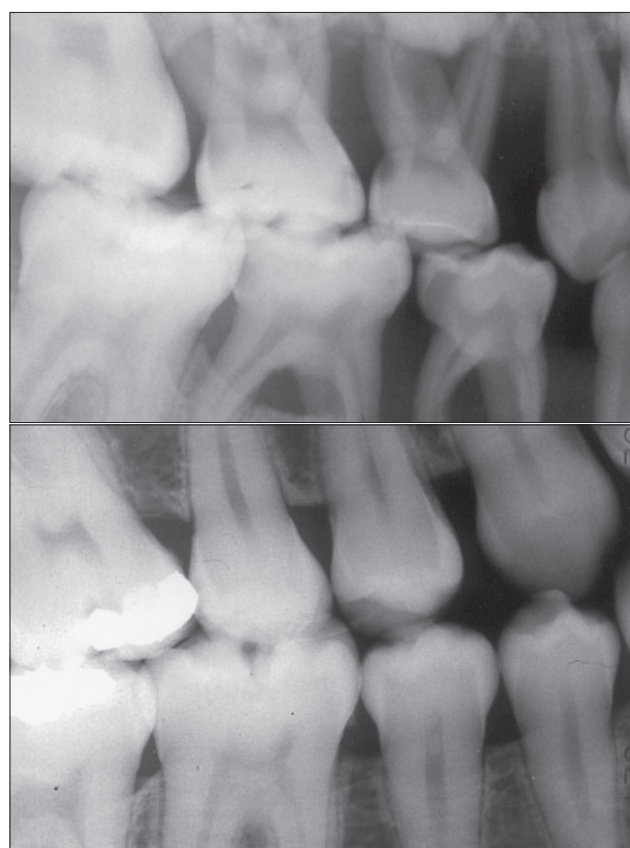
Bite-wing radiographs of case No. 1 at beginning and end of the follow-up (1995 and 2002, respectively). Extensive alveolar bone loss is evident in the primary teeth in the initial radiograph; a normal periodontium is evident in the permanent dentition.
